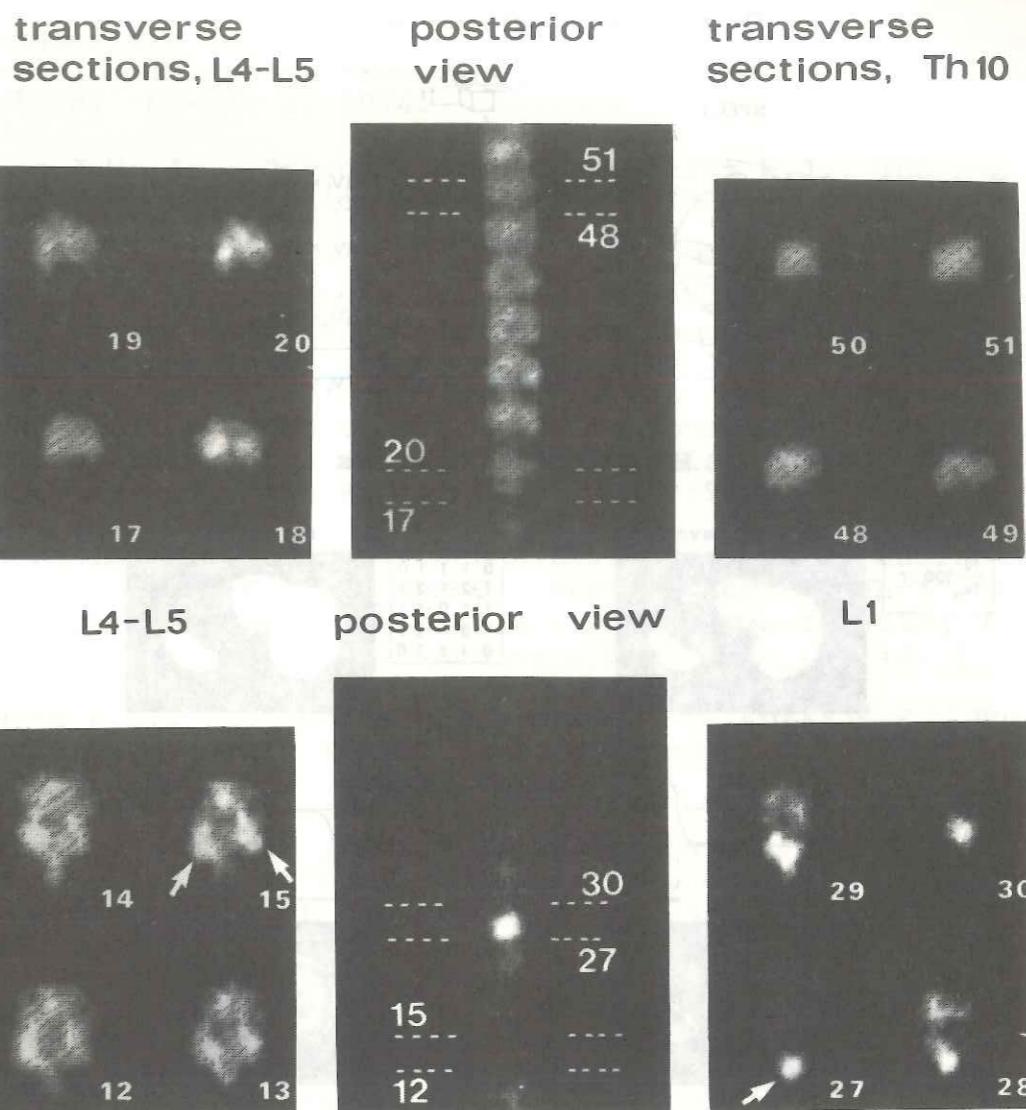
SPECT examinations of the spine with 350 MBq $^{99}\text{Tc}^{\text{m}}$ -MDP. Above: Normal case. Below: High uptake of the intervertebral joints in section 15 to the left (arrows) and of the spinous process at L1 (section 27 to the right). The latter uptake is also seen on the posterior view.
